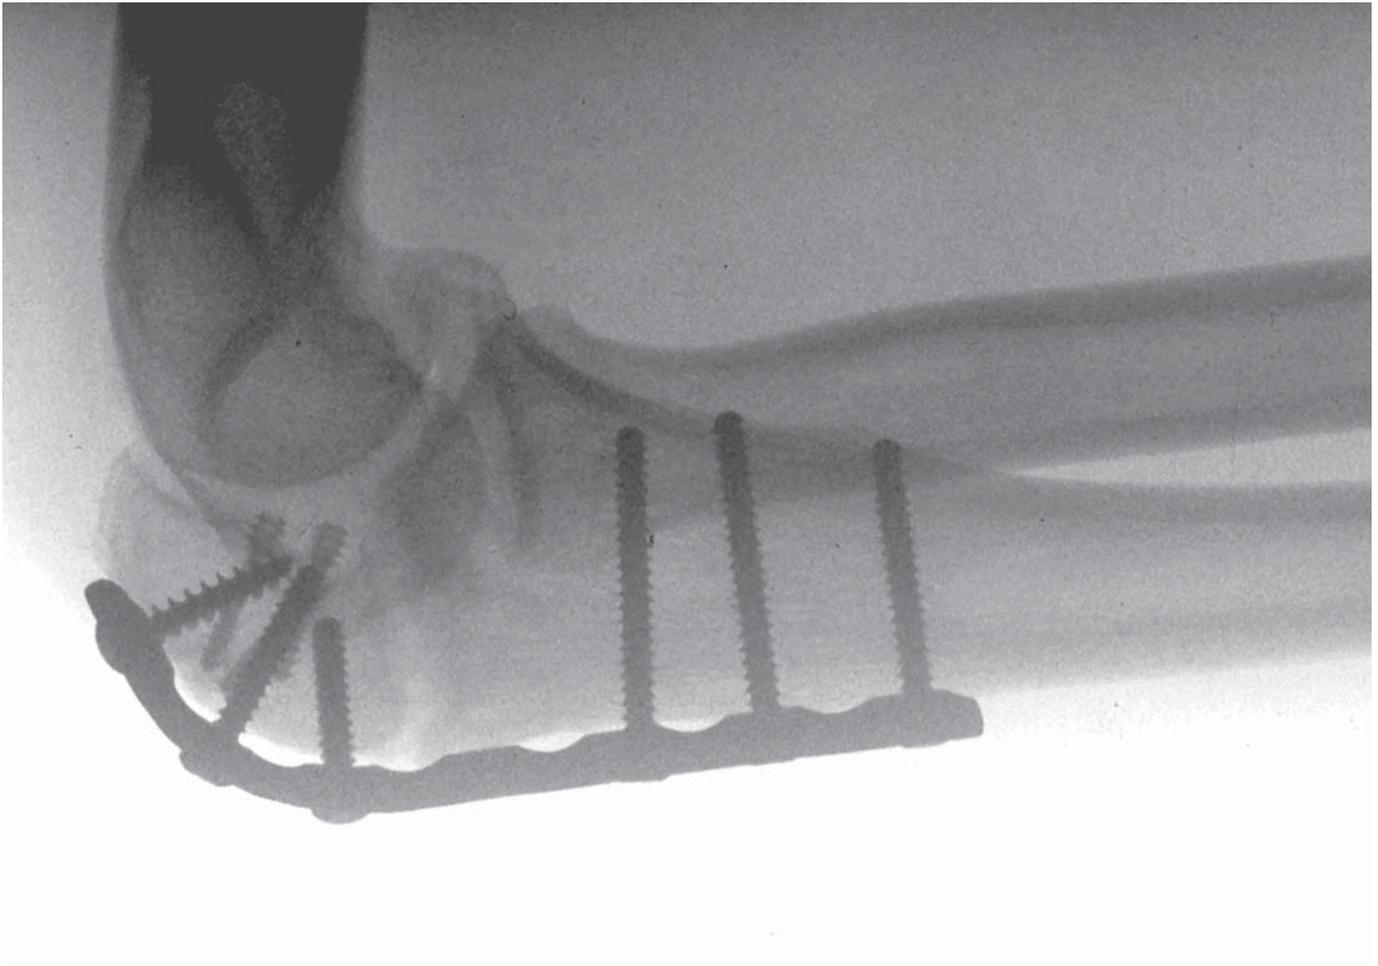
Postoperative lateral xray of the elbow revealing reconstruction construct with the osteochondral allograft.
